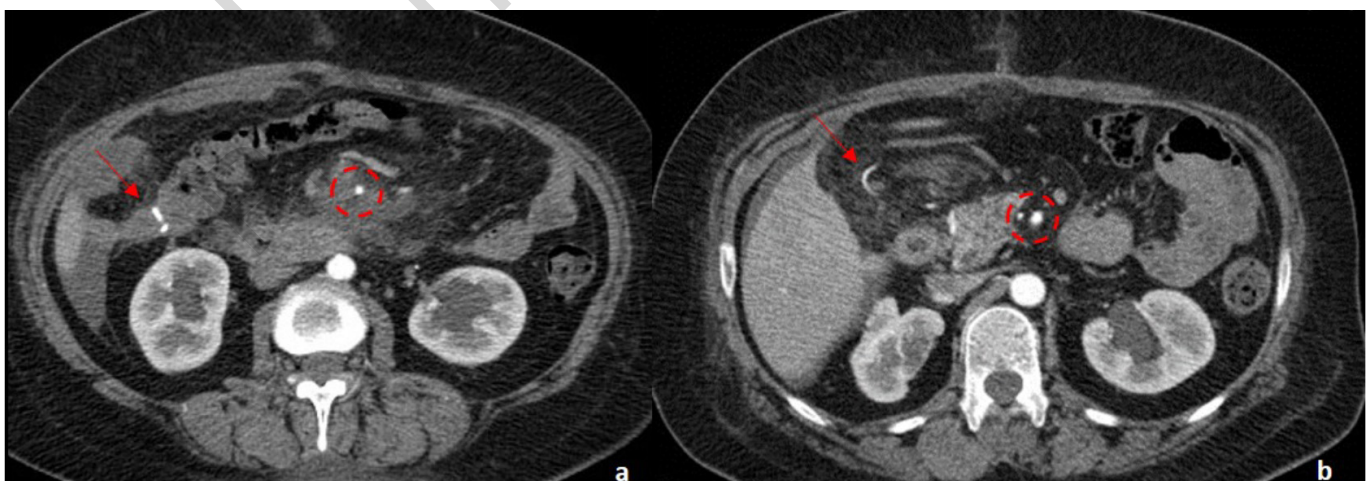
CT scan acquired on postoperative day 7: A) complete thrombosis of the superior mesenteric vein (red circle), with no signs of visceral damage (red arrow); B) n.
